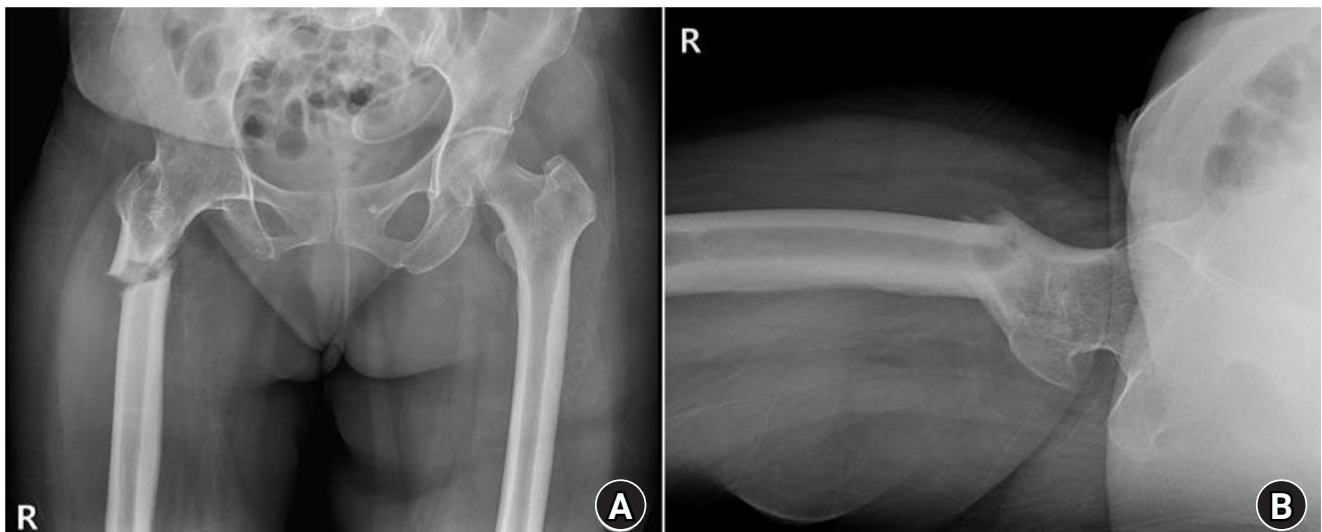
Radiographs of the same patient presenting with a right subtrochanteric femoral fracture (Russell-Taylor classification type 1). (A) Anteroposterior view. (B) Axial view.
